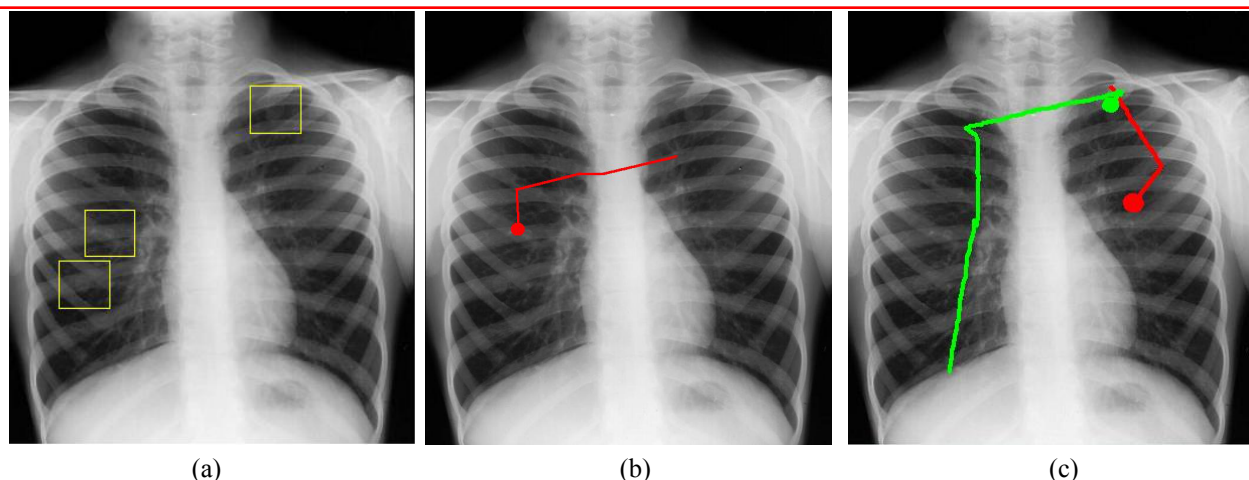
a) Chest x-ray with three pulmonary nodules highlighted. b) 500ms of pre-recorded eye movement taken from an experienced radiologist as they searched for nodules. c) A novice radiographer's current eye movements (upper circle) as they follow the radiologist's eye movement patterns (lower circle). Lines from circles indicate previous fixation locations.
